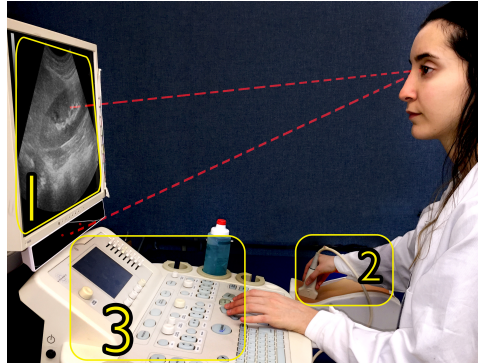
The Setting of a Diagnostic Sonographer's Environment and the Sonographer's Three Contexts of Attention: the Ultrasound Image, the Patient and the Machine Controls.
